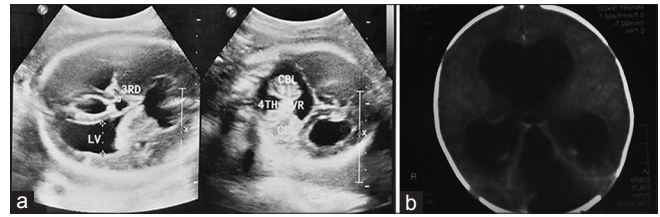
(a) Prenatal USG at 34th week of gestation showed dilated 3rd and 4th ventricle with a posterior fossa cyst, communicating with 4th ventricle and (b) computed tomography scan of the brain showing enlarged 3rd and 4th ventricle with a posterior fossa cyst
